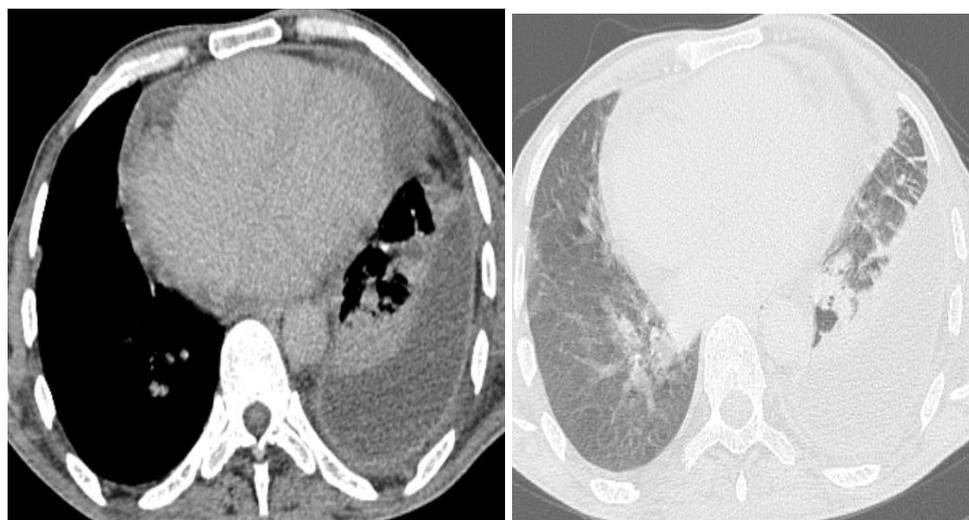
Axial CT (mediastinal and lung windows) showing moderate pleural and pericardial effusions with enhancing pleural thickening and adjacent atelectasis
